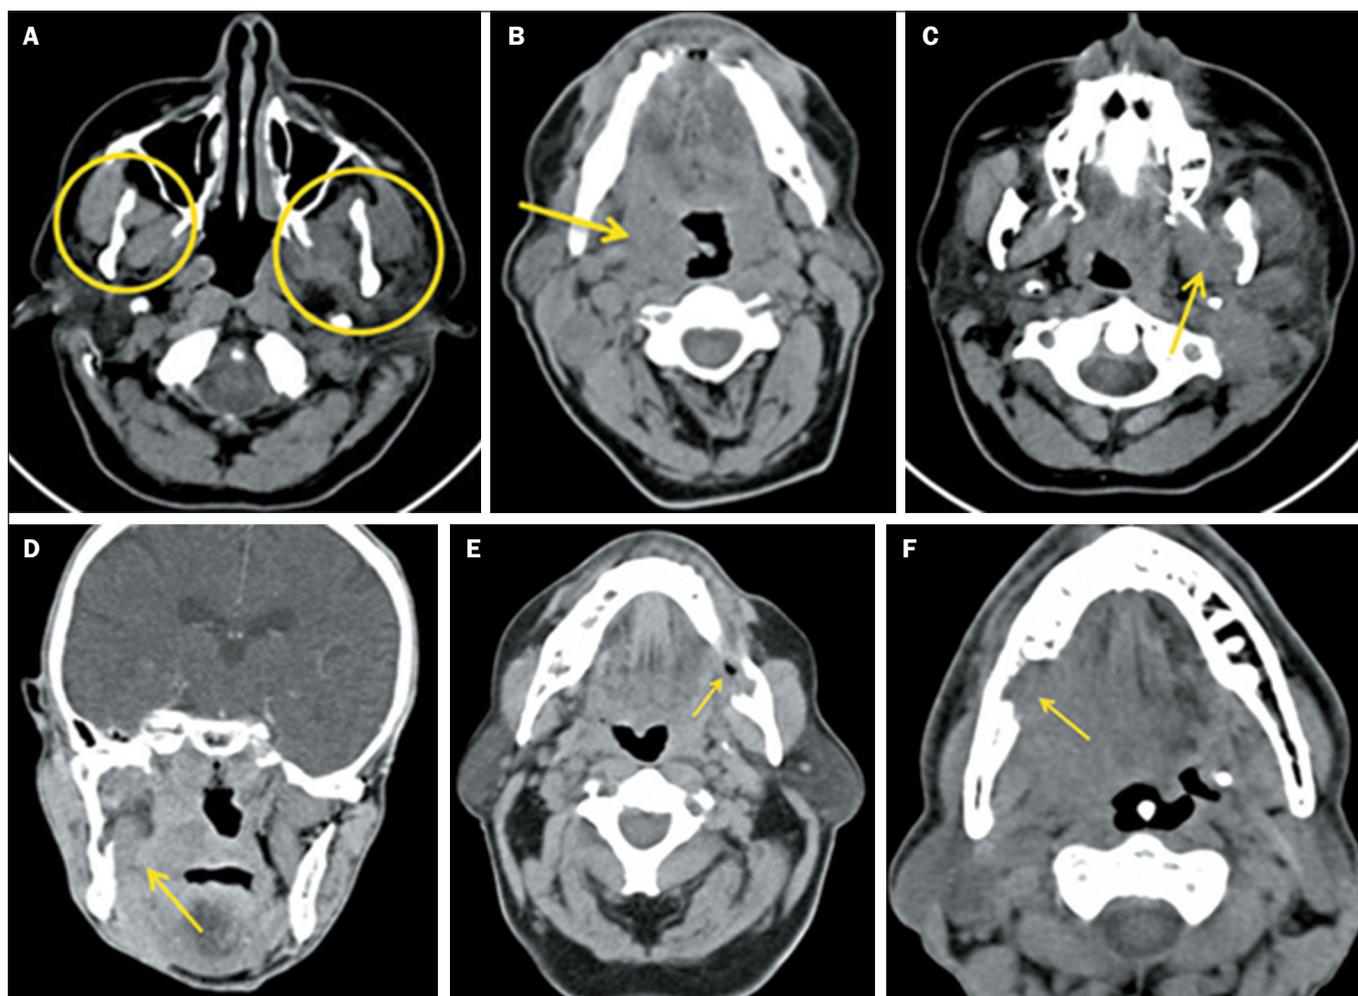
A–C: Axial CT slices with soft-tissue window settings, demonstrating asymmetry in relation to the contralateral masticator space (A), obliteration of the pharyngeal fat plane (B), edema of the medial pterygoid muscle, and invasion of the mandibular canal by the tumor (C). D: Coronal CT slice with a soft-tissue window setting, showing edema of the medial pterygoid muscle. E,F: Axial CT slices with bone-tissue window settings, showing destruction of the mandibular ramus.
